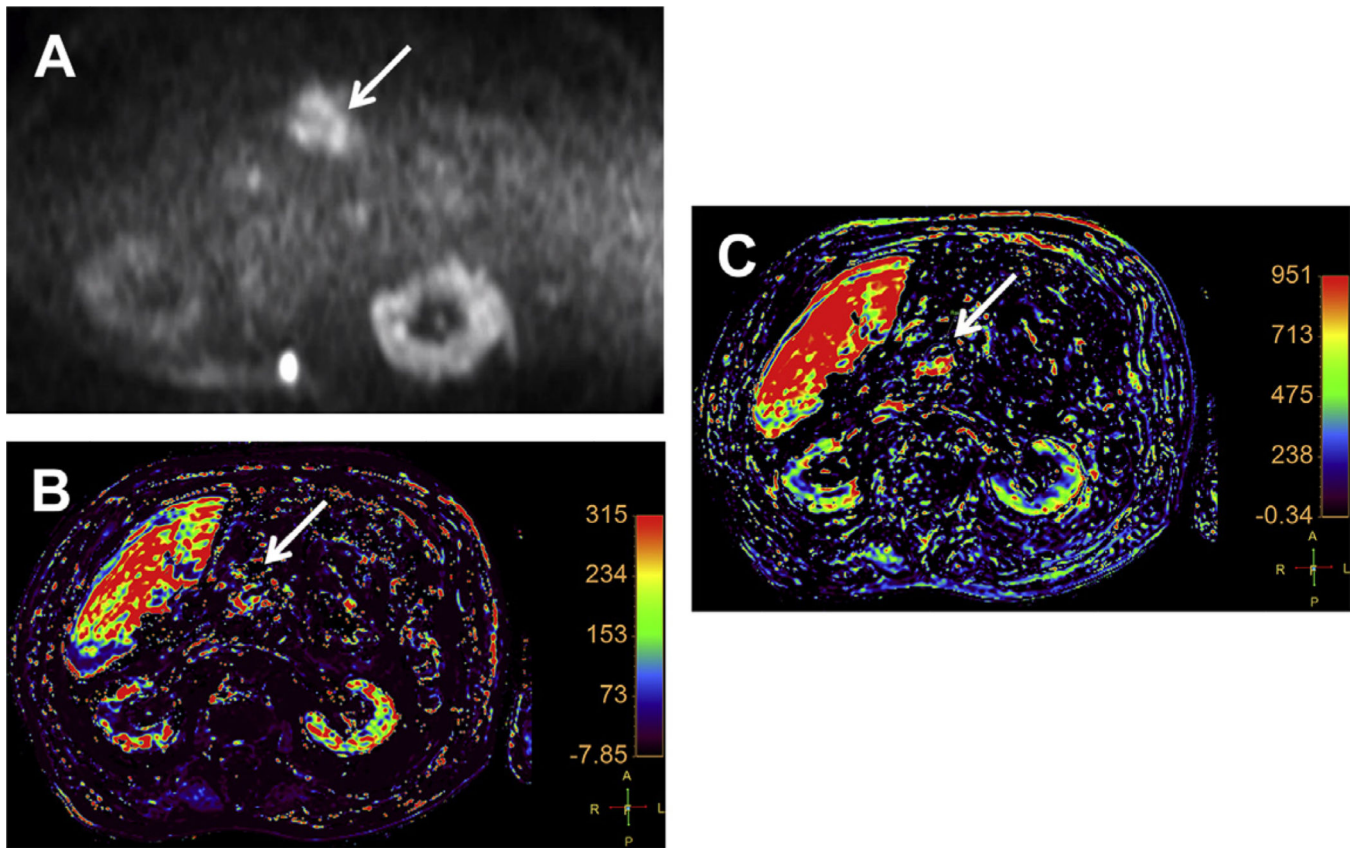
DCE-MR imaging in 79 year-old man with pancreatic cancer (*arrows*). (A) DWI with b value of 800 s/mm² shows a pancreatic mass with high signal intensity. (B, C) K^{trans} and k_{ep} parametric maps respectively, obtained using a bicompartamental model from DCE-MR imaging, show elevated values of both biomarkers, suggesting a potential good response of this tumor to antiangiogenic drugs.
